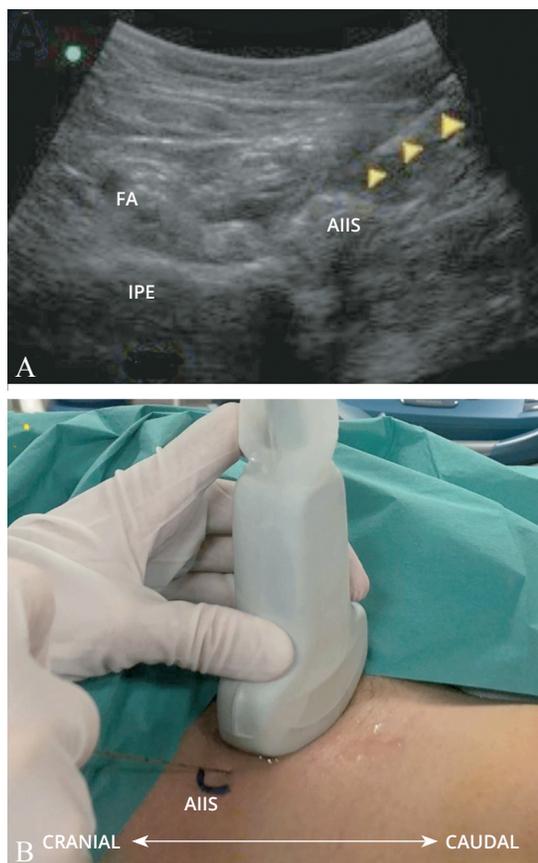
A) Sonoanatomy; B) anatomical location of the ultrasound probe in the PENG block. AIIS: antero-inferior iliac spine; FA: femoral artery; IPE: iliopectineal eminence; triangles: needle tip in the direction of the tendon of the psoas muscle.
